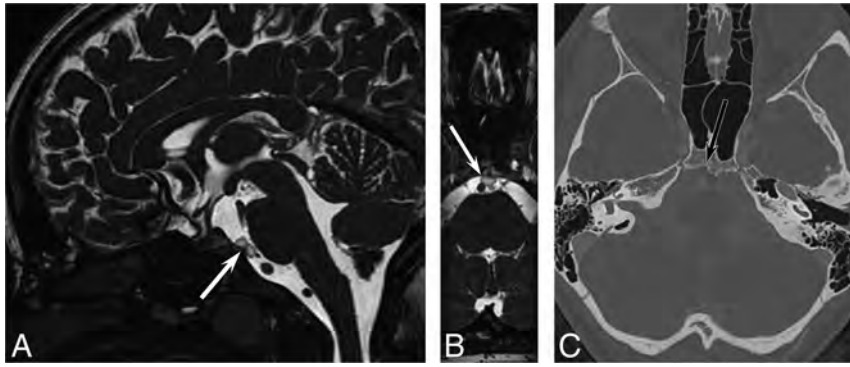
A 16-year-old girl with headaches. A, Sagittal steady-state free precession MR imaging shows a lobular, well-defined T2-hyperintense lesion (arrow) in the prepontine cistern. Axial reformatted image (B) shows a benign-appearing abutment to the clivus. Axial CT (C) shows slight remodeling of the posterior clivus without erosion.
